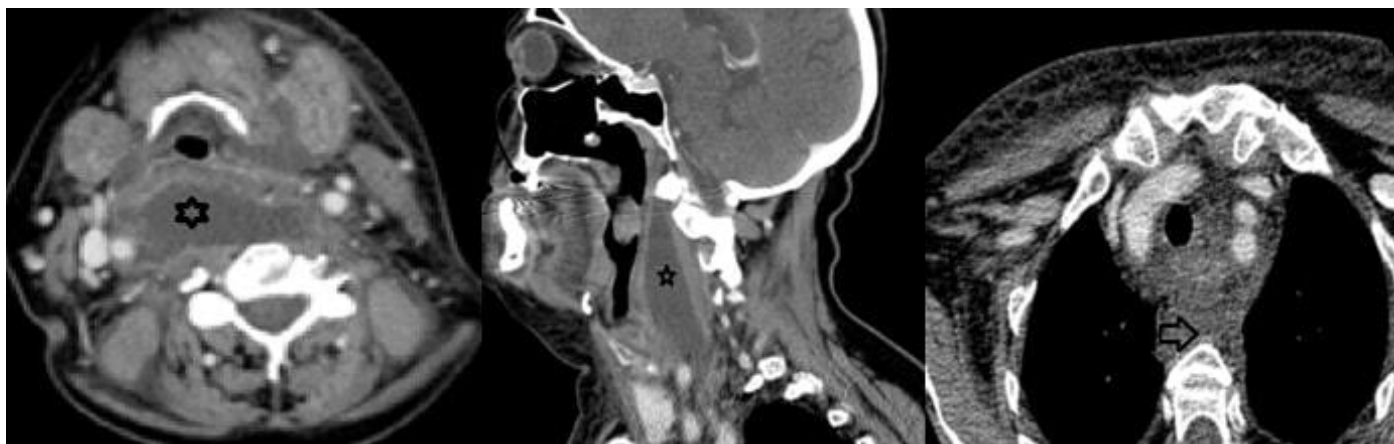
Axial and sagittal CT images of a patient with retropharyngeal abscess and mediastinitis (asterisk, retropharyngeal abscess; arrow, mediastinitis).
